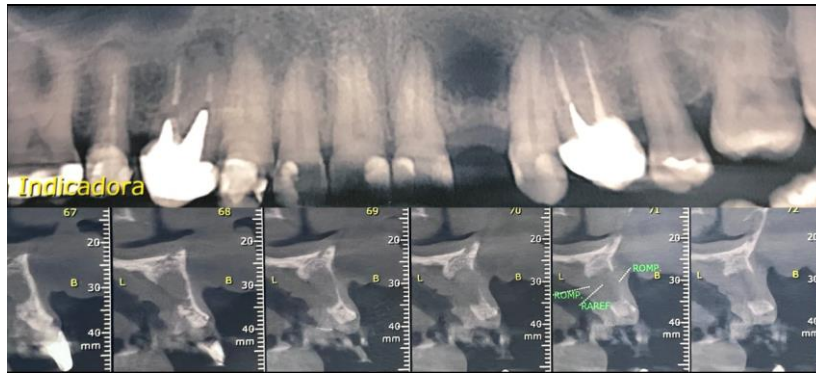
Cone Beam type CT scan revealing the need of bone thickness volume gain due to the local bone defect.
